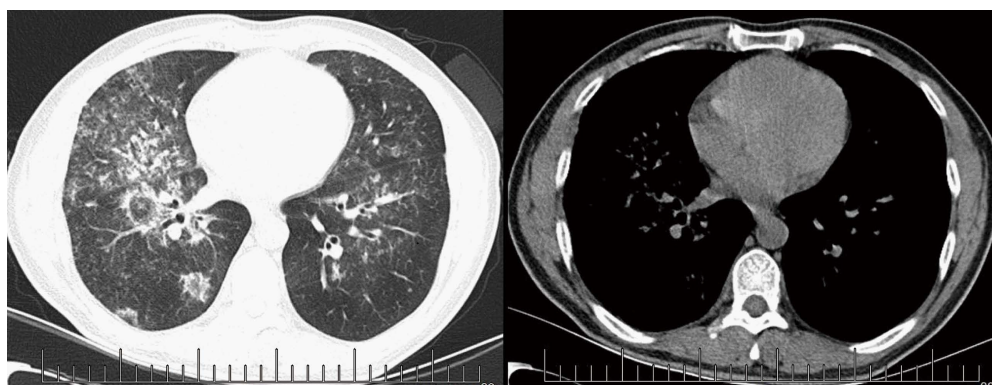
Pulmonary computed tomography images showing bilateral consolidation with air-bronchogram, especially in the right lung with multiple ground glass low-density shadows.
